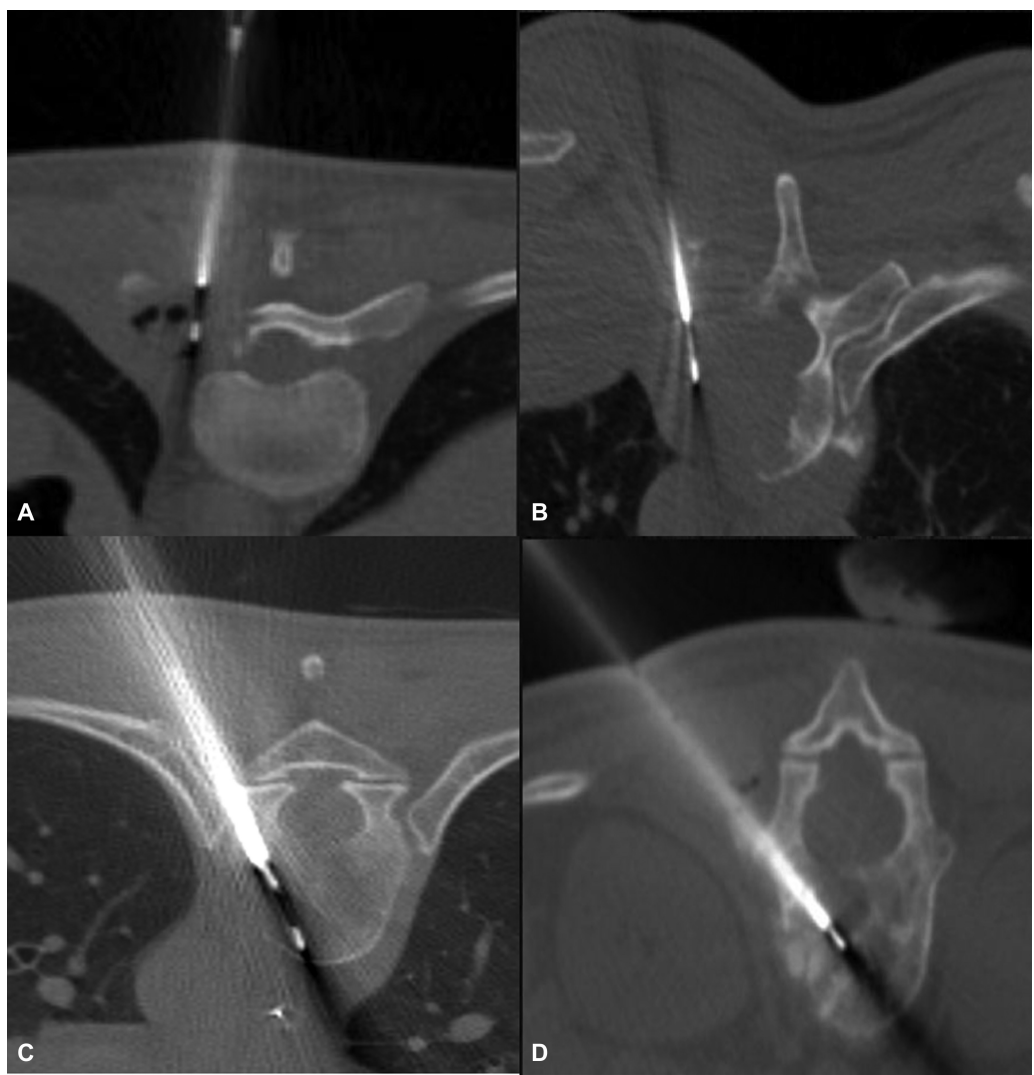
(A and B) Axial CT images demonstrate vertebral lesion biopsy by parapedicular technique. (C and D) Axial CT images demonstrate vertebral lesion biopsy by transpedicular technique.
